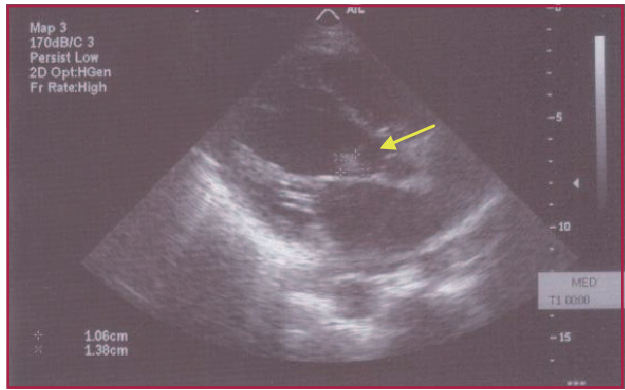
Transthoracic echocardiography. Parasternal long axis view showing vegetation of 1.0 x 1.3 cm diameter attached to the ventricular wall is observed, close to the left ventricular outflow tract.
